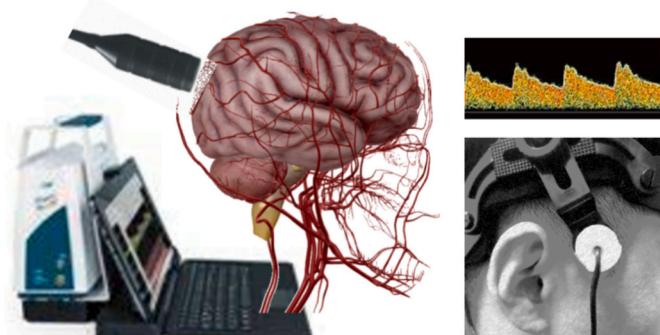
Cerebrovascular function tests with transcranial Doppler.
